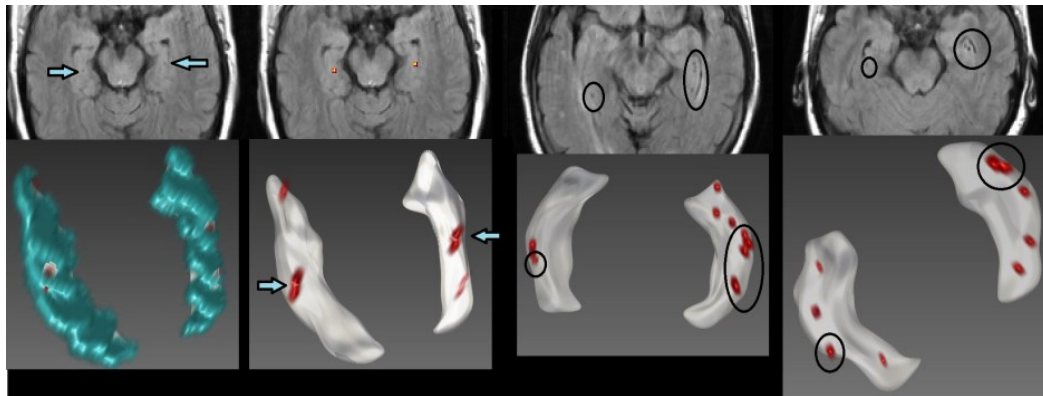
Three examples of the distribution of FLAIR hypointensities/T2-weighted hyperintensities on representations of their respective hippocampi. Arrows point to hippocavities penetrating the hippocampi. Encircled are hippocavities on the surface. The blue surface is the 3D representation of the binary mask.
